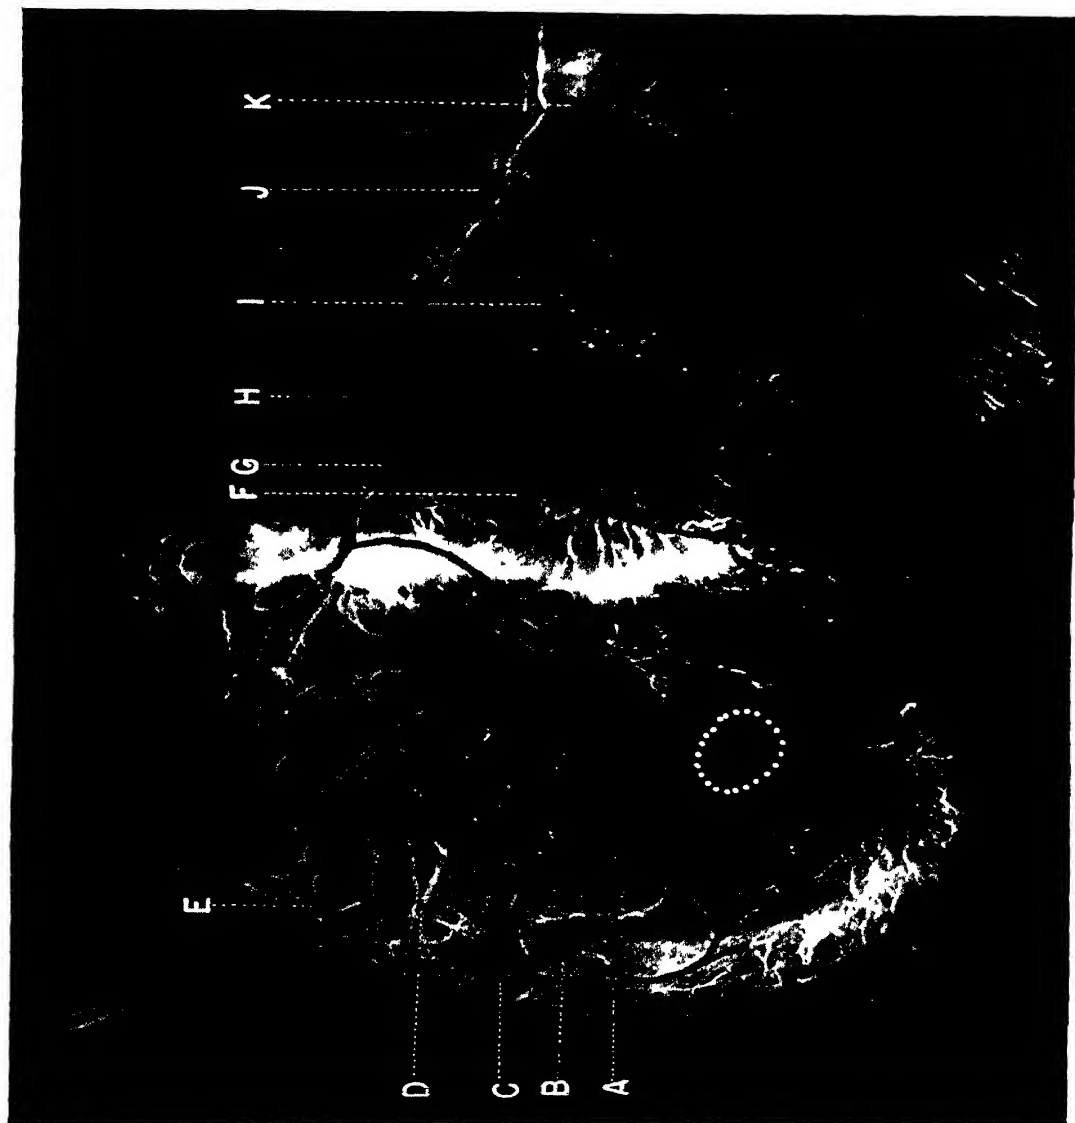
Copy of roentgenogram of injected and unrolled heart, with arteries tinted to indicate color identified by dissection (Blungart, Schlesinger and Davis Am Heart J )
